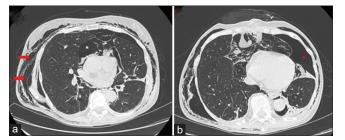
Thoracal computed tomography scan showing: (a) Subcutaneous emphysema (red arrow) and pneumomediastinum (white asterisk); (b) Left-sided pneumothorax (red asterisk)
